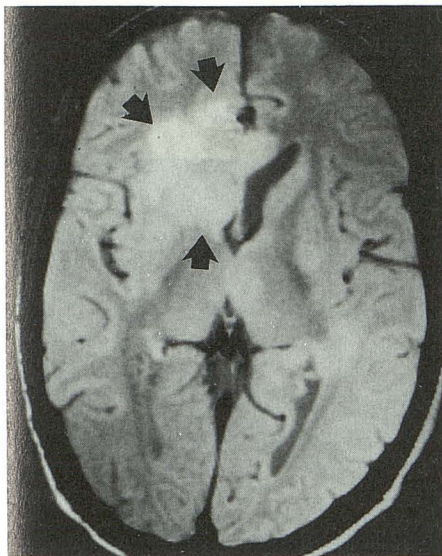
Case 32: 27-year-old man admitted with persistent headaches. CT scan (not shown) revealed a hypodense lesion in the head of the right caudate nucleus. Proton-density MR image (2000/20) shows hyperintense lesion involving the right caudate nucleus and its surrounding tissue with involvement of the corpus callosum. Biopsy proved primary CNS lymphoma.
